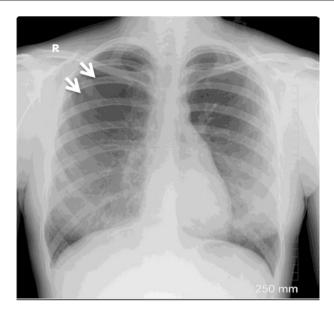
Erect PA chest radiograph showing a spontaneous right-sided apical pneumothorax in a 32-year old patient. Arrows demonstrate the visceral pleural line. Note the absence of lung vascular markings peripheral to this line
